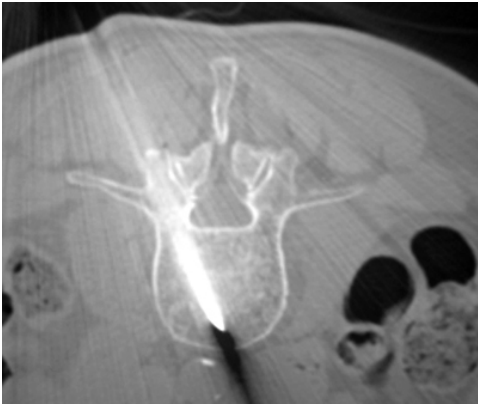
CT control. The needle is placed in the anterior one-third of the vertebral body.
